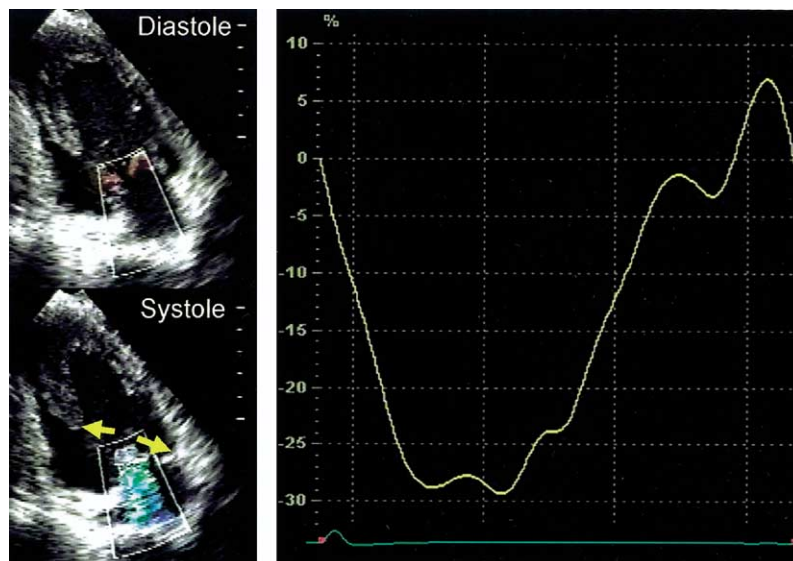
A patient with significant ischemic mitral regurgitation (MR) despite good papillary muscle (PM) function shown by normal systolic PM thickening on two-dimensional echocardiography (left upper and lower panels) and normal systolic PM longitudinal shortening with strain imaging (right panel). The medial PM tethering distance (arrows) is long and can explain the MR.
